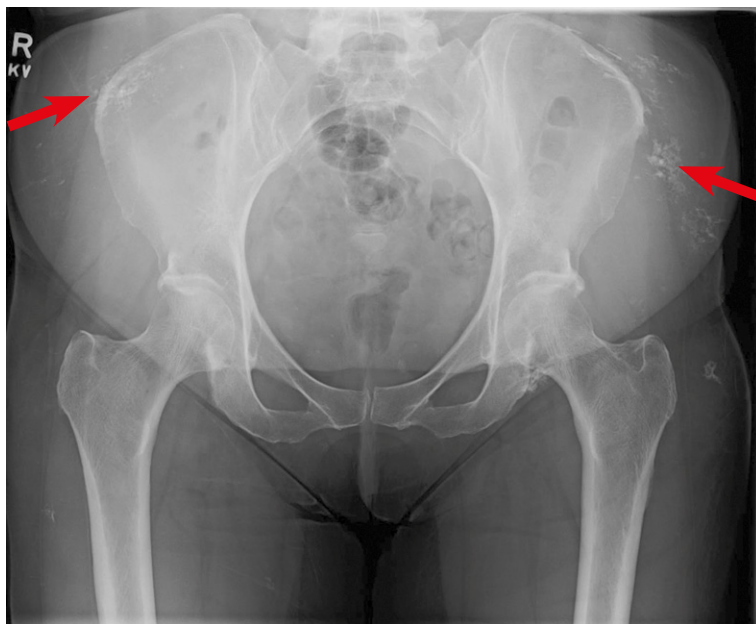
Dystrophic calcifications secondary to dermatomyositis are seen in the peripheral soft tissue (2 red arrows). They appear as hazy ill-defined opacities on plain film.
